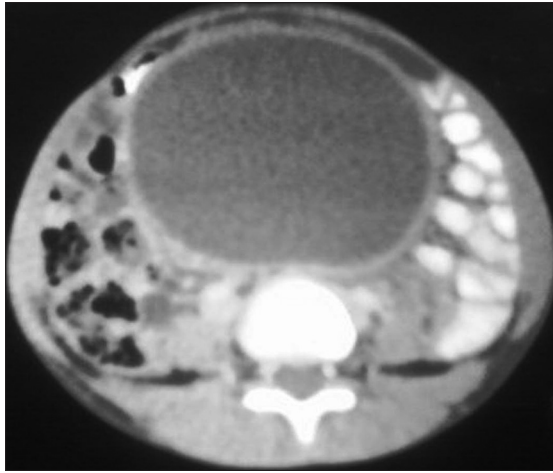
Contrast-enhanced computed tomography showed a huge, cystic mass behind the bladder
